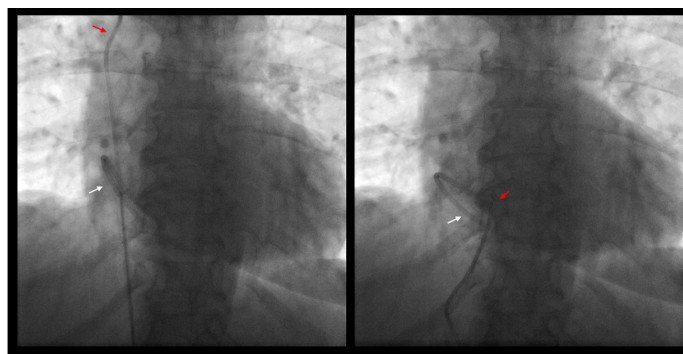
Plain radiographs show the embolized port catheter (white arrows) a modified Simmons type 2 diagnostic catheter with a manually trimmed distal tip (red arrows), which enhances maneuverability and allows precise navigation toward the dislodged fragment during endovascular retrieval.
